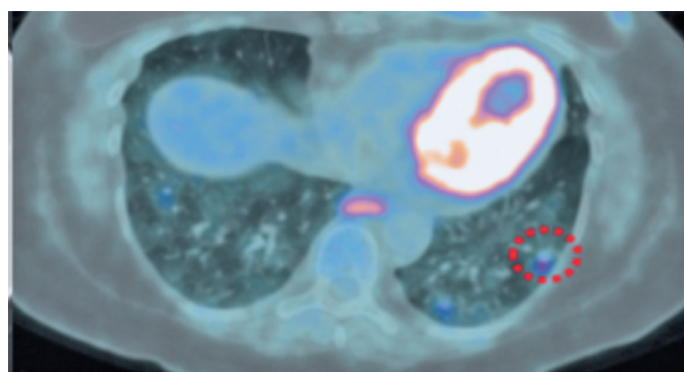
Numerous FDG-avid pulmonary nodules are highlighted by red circles. Despite their small size, these nodules were considered highly suspicious due to a history of high-risk breast cancer, previous images showing no such alterations, and the presence of other suspicious lesions (extrapulmonary)
